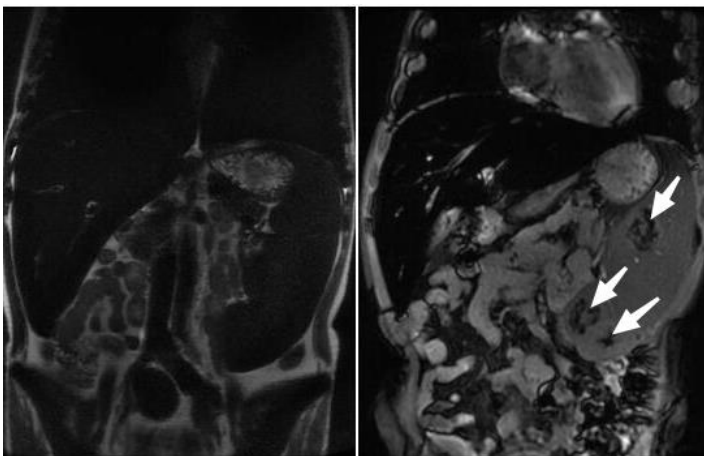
The MRI showed severely hepatosplenomegaly and the liver was markedly hypointense on both MRI T1 and T2 weighted sequences, in keeping with iron overload. There were several small heterogeneous hypointense focus (white arrows) on the spleen which were suggestive of extramedullary hematopoiesis.
